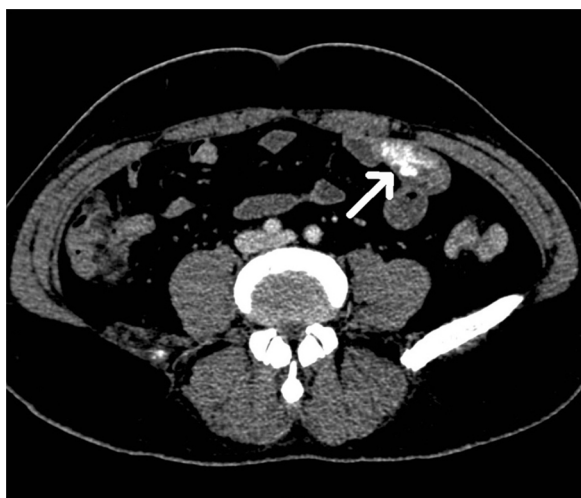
Axial section of CT abdomen (portal phase) showing hypervascular lesion in ileum.
